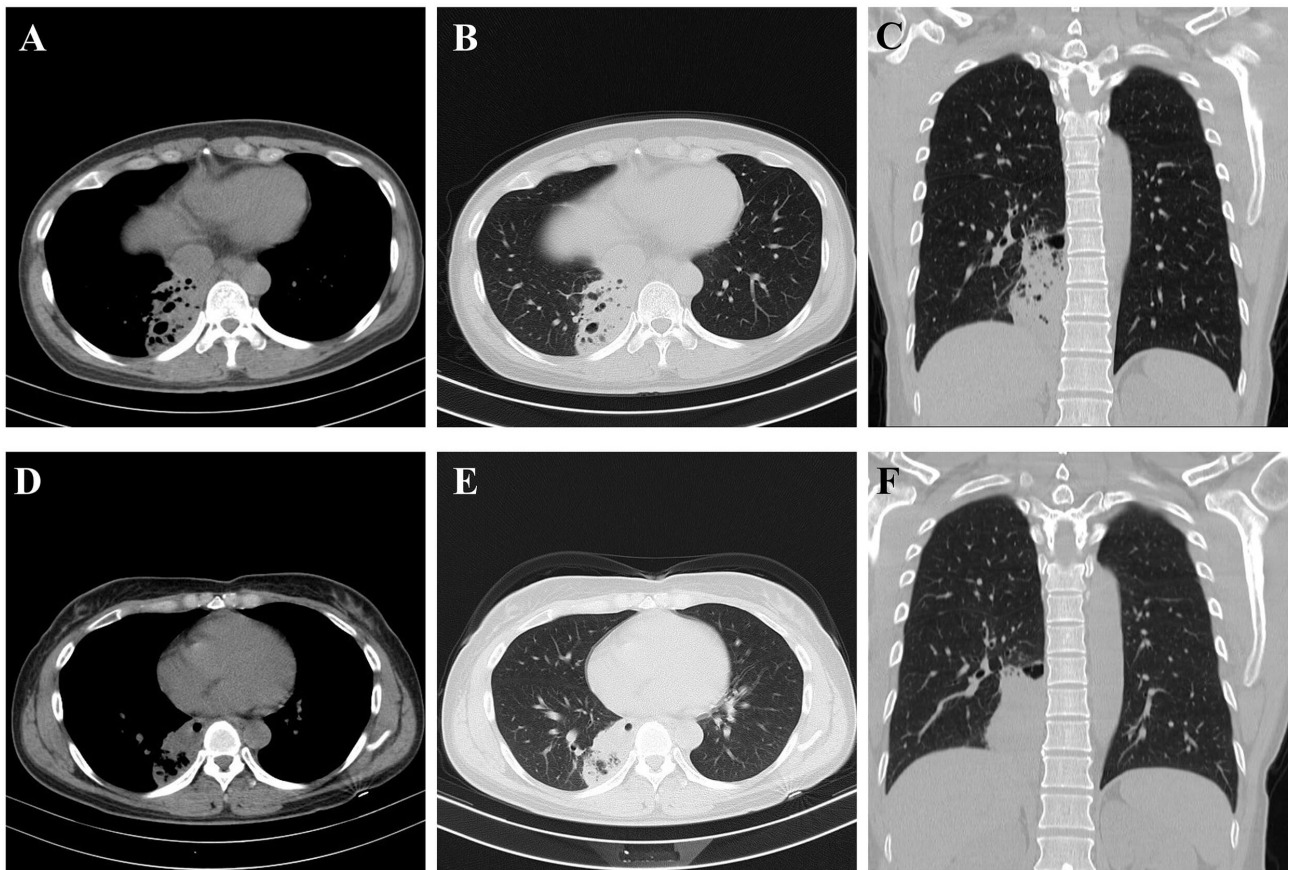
Serial chest CT findings during initial presentation and disease progression. (A–C) Initial non-contrast chest CT performed at the first admission showing localized bronchiectatic changes with associated infection in the right lower lobe. Axial (A,B) and coronal (C) images demonstrate inflammatory changes involving the posterior basal region of the right lower lobe. (D–F) Repeat chest CT performed after readmission revealing progression of the right lower lobe lesion compared with the initial examination, despite temporary clinical improvement following anti-infective treatment. CT, computed tomography.
